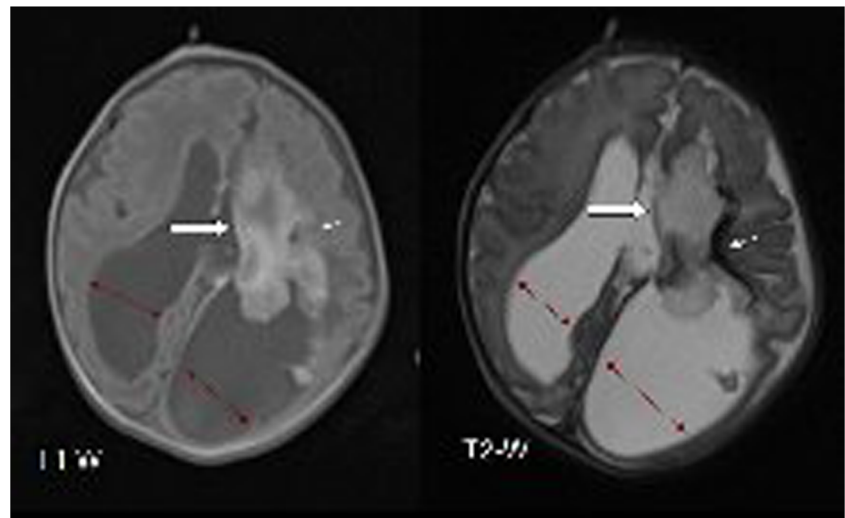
Postnatal brain MRI of 1-day-old boy: grade IV hemorrhage is shown with late subacute intraventricular hemorrhage (white arrows) with hydrocephaly (black arrows) which is hyperintense on T1-W and hypointense on T2-W axial image with chronic parenchymal hemorrhage on left frontoparietal periventricular region (small arrows)
